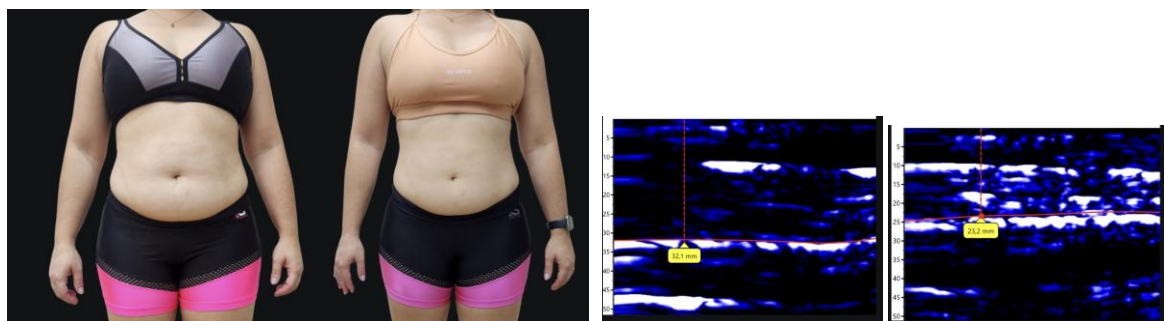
Patient 2: photographic and ultrasound documentation before and after the protocol (32.1 and 23.2 mm). Images from the author's clinical records, published with the patient's authorization.
